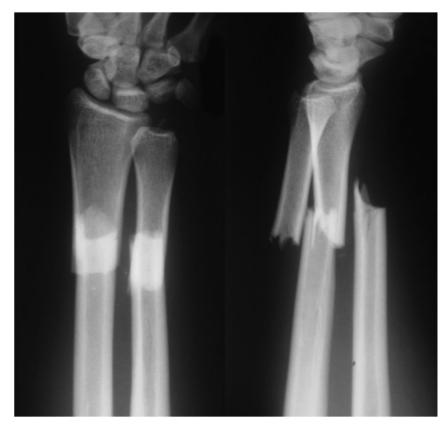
Radiographs (anteroposterior and lateral view) showing a fracture of the left distal radius and ulna.
